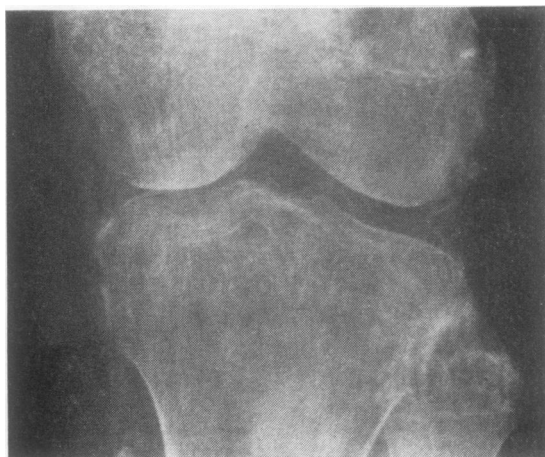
Case 1. Radiograph of the left knee showing evidence of chondrocalcinosis.
